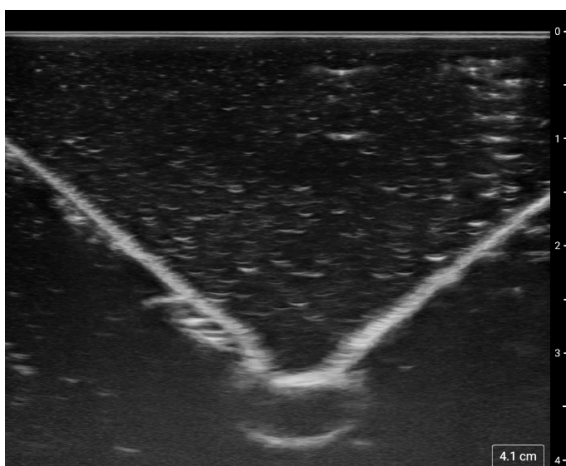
Unlabeled adductor canal ultrasound sonotomography image with embedded anatomic structures.
